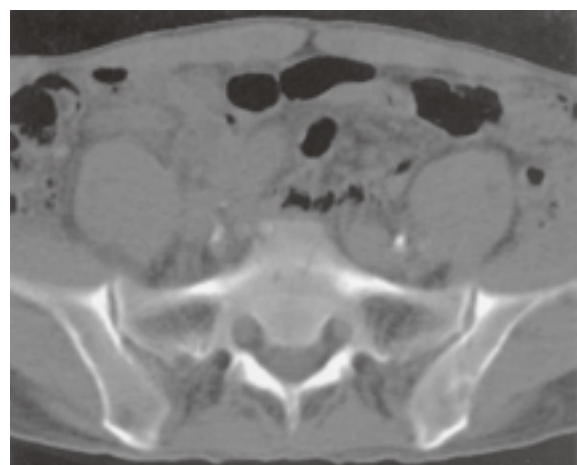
CT (bone window) of the same patient as in Fig. 3a shows a corresponding lytic lesion in the left iliac bone.
